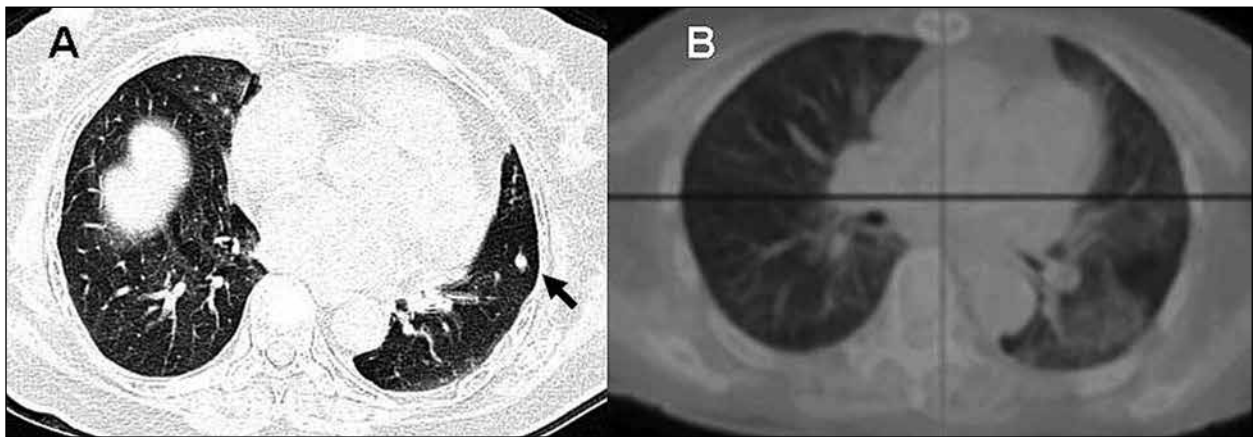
(A): Chest CT scan: nodular lesion 0.7 centimeter (cm) in the left lower lobe of lung (black arrow), (B):  $^{18}\text{F}$ -FDG PET: no abnormality in FDG uptake area.
